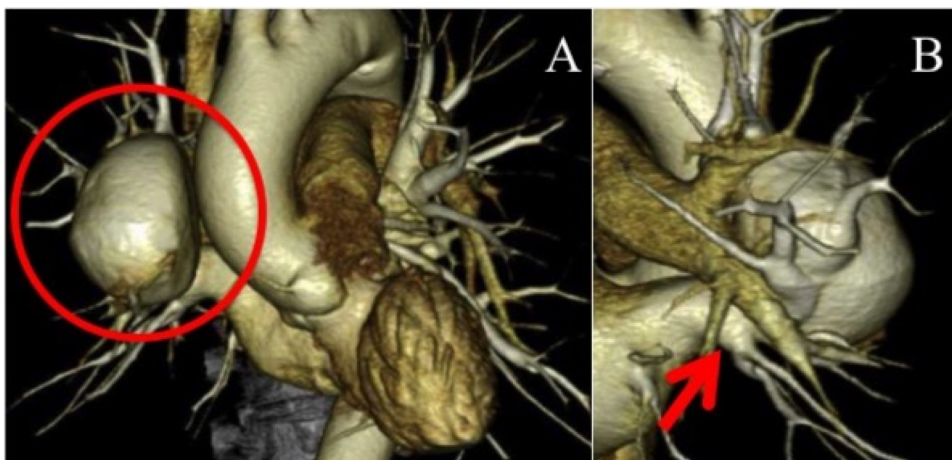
A) 3AD-CT demonstrating a large pulmonary aneurysm (circle). B) EBach segmental pulmonary vein flowing into the aneurysm independently. The distance between the right middle lobe vein and the aneurysm was sufficient to be free from stricture. The right upper lobe vein was resected at normal venous wall and the middle lobe vein could be conserved (arrow).
